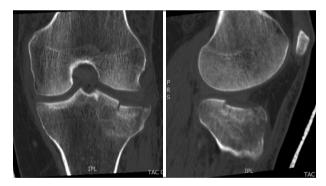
Pre-operative CT scan showing a Schatzker type III fracture
